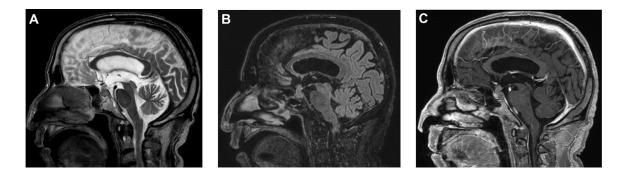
(A-C). 12 weeks after CRT treatment, sagittal plane TSE T2 (A), FLAIR (B) and T1 post contrast (C) sequences show a discrete dimensional reduction of the known pituitary lesion, especially in its suprasellar component.
